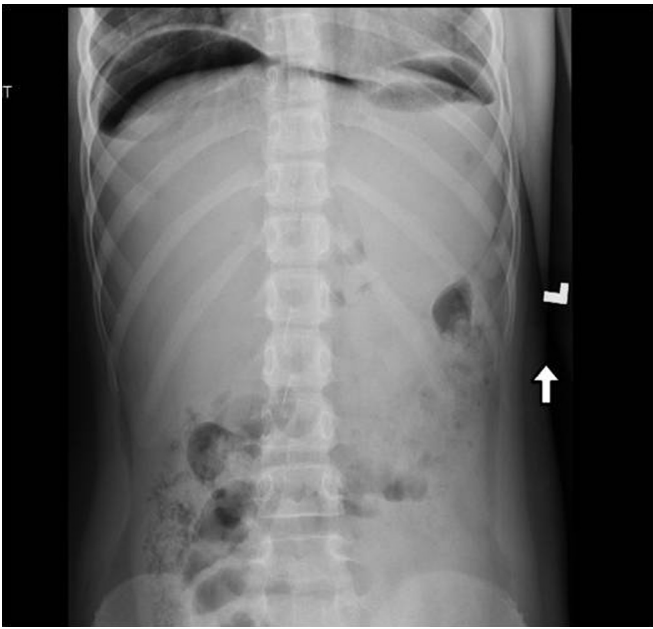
Upright abdominal x-ray showing pneumoperitoneum.
